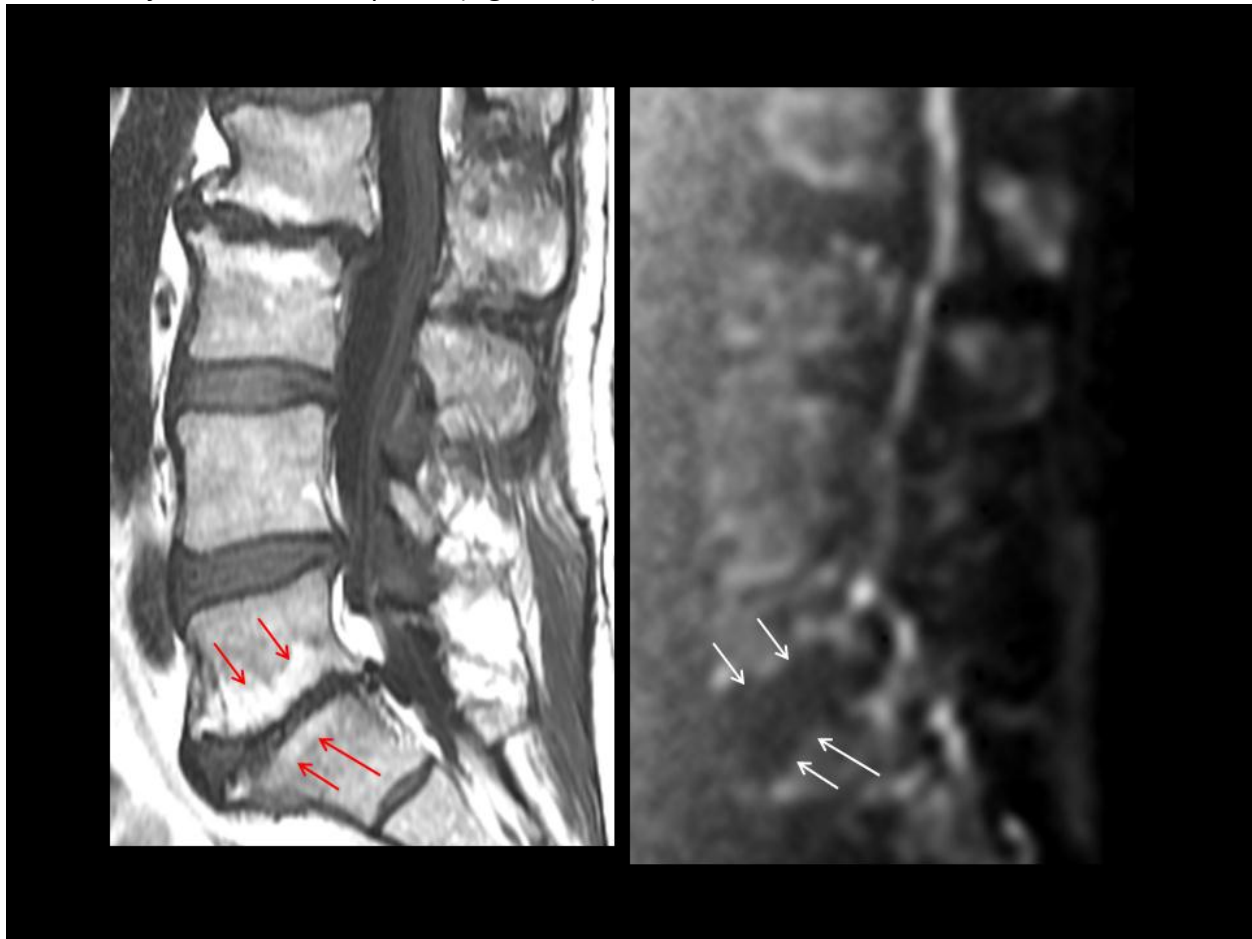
Type II Modic changes. T1 FLAIR (left) and DWI. Note the characteristic fatty changes on T1WI that manifest as diminished signal on the (routinely) fat suppressed DWI creating the appearance of a widened disc space.
